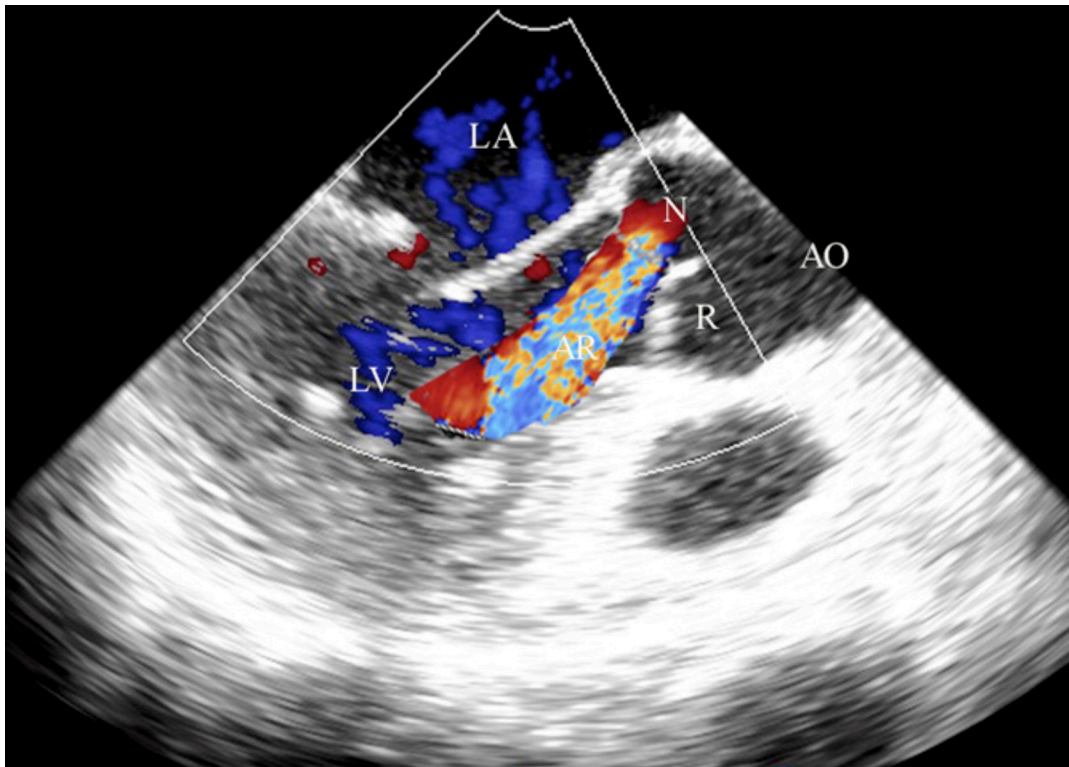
Color Doppler evaluation revealed severe aortic regurgitation that originated from a perforation in the noncoronary cusp. LA indicates left atrium; LV, left ventricle; AO, aorta; R, right coronary cusp; L, left coronary cusp.
